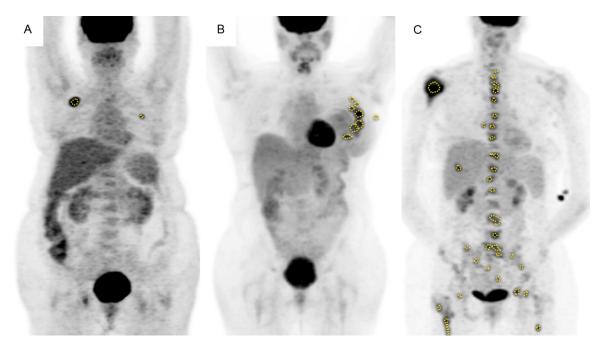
Measurement of Metabolic Tumor Volume. Representative PET MIP of two patients at time of FDG PET/CT: (A) Low tumor burden: MTV of 36.0 ml, with survival of 669 days; (B) Medium burden: MTV of 58.3 ml and survival of 393 days; and (C) high tumor burden: MTV of 137.0 ml with survival of 16 days.
